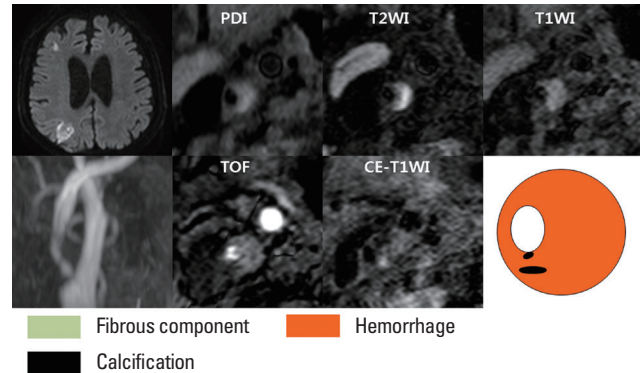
Vulnerable plaque. Axial diffusion-weighted magnetic resonance (MR) image of the brain (top right) and MR angiographic image (bottom right) showing high-grade carotid stenosis with ipsilateral acute infarction. Axial MR images obtained by using five pulse sequences show that the plaque contains three components. A large recent hemorrhage is hyperintense on T1- and T2-weighted imaging, proton-density imaging, and TOF imaging, and multifocal calcifications are hypointense in all sequences. PDI, proton density image; T2WI, T2-weighted image; T1WI, T1-weighted image; TOF, time-of-flight image; CE-T1WI, contrast enhanced T1-weighted image.
